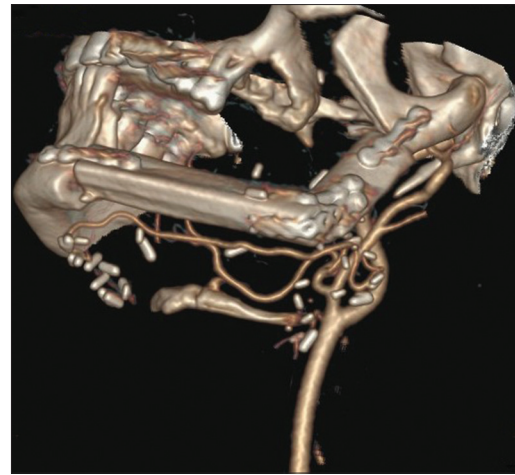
Late CT-Angio picture of the peroneal artery (Lateral view) showing the anastomosed distal end
